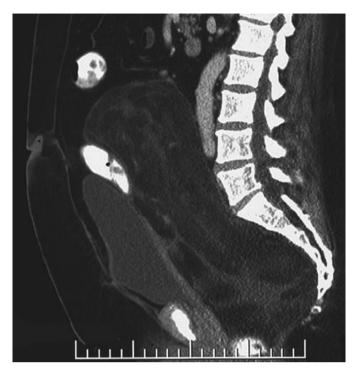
Contrast-enhanced Computed Tomography: large retroperitoneal tumour (sagittal view).
